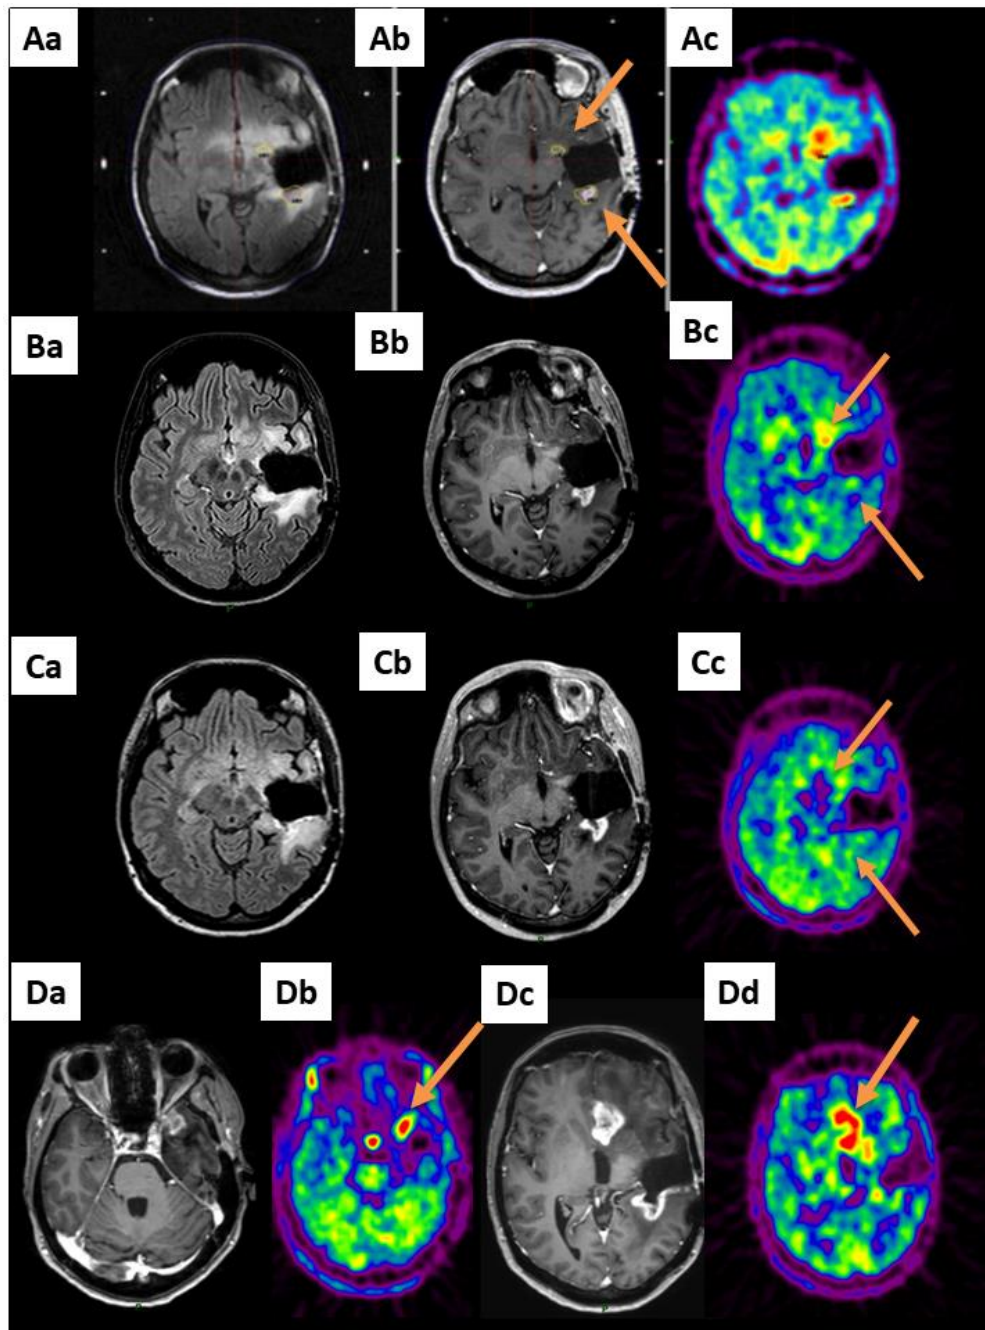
A 42-year-old patient (patient 7 in Table S1) already treated by the Stupp protocol for left temporal glioblastoma after large surgery presented with a radiological progression located in the operative cavity wall 6 months after her diagnosis (2 spots, arrows). A GKRS treatment, 15 Gy covering a total volume of 2932 mm³ including the 2 MET-PET targets, was performed. Aa: MRI reformatted axial FLAIR, Ab: reformatted axial T1-weighted with contrast and Ac: MET-PET study on the day of the GKRS treatment (2 targets, arrows). B and C show the same sequences 3 and 6 months after GKRS, respectively. Three months (B) and 6 months (C) after GKRS, the metabolic exams revealed a local response. However, six months after the treatment, the MRI and MET PET exams revealed remote progression (Da and Dc: axial T1-weighted with contrast and Db and Dd: MET-PET).
